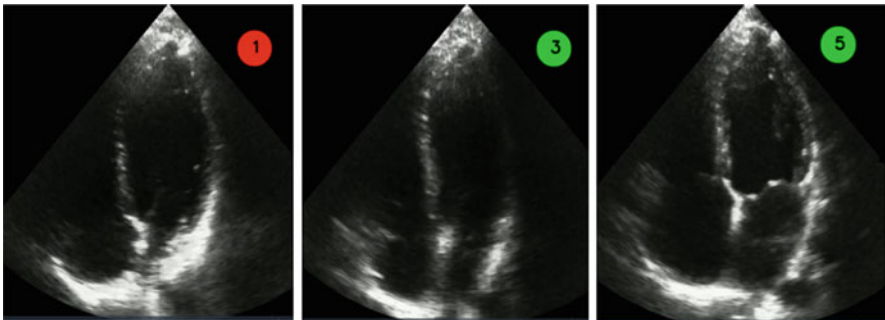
Apical 4 chamber view evaluated by artificial intelligence. Left panel: a poor image with a score of 1. Middle panel: an acceptable image with a score of 3. Right panel: an excellent image with a score of 5
